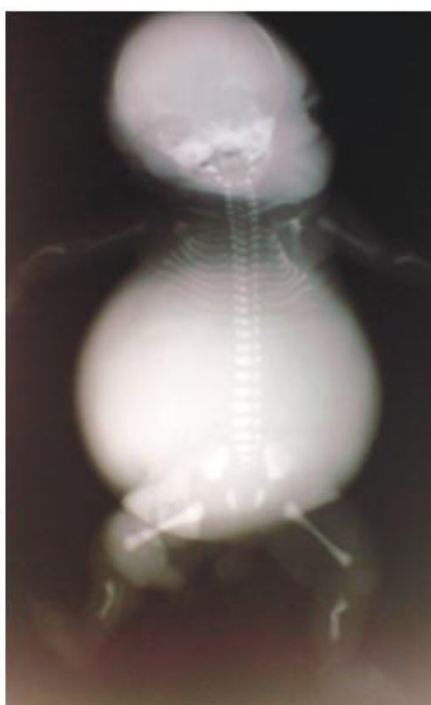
Radiographic picture of thanatophotic dysplasia
